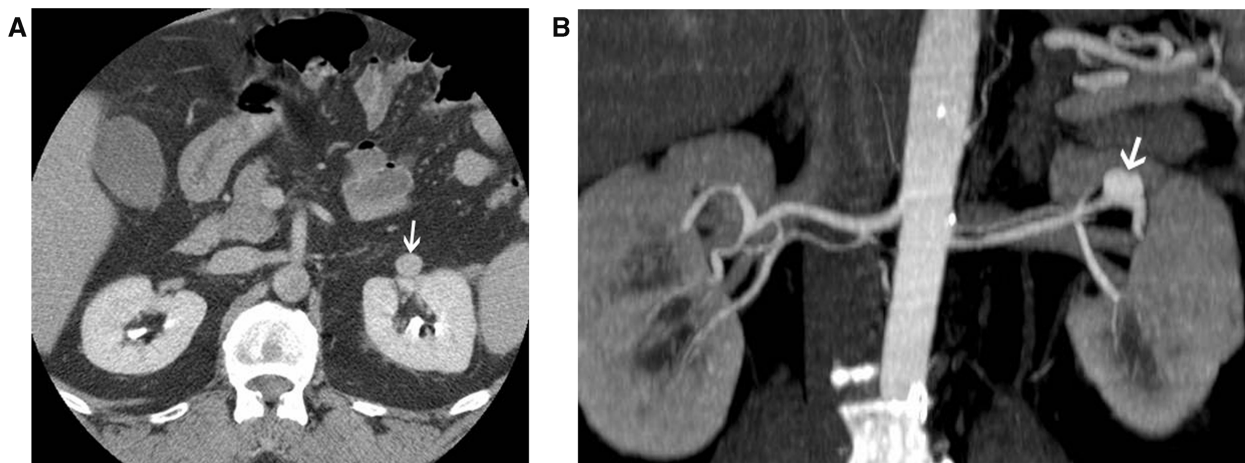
Contrast-enhanced axial CT during the nephrographic phase (A) showing a homogeneous enhancing mass (arrow) in the left renal hilum. A dedicated CT with arterial phase imaging with reformatted images (B) shows that the lesion is a pseudoaneurysm (arrow).
